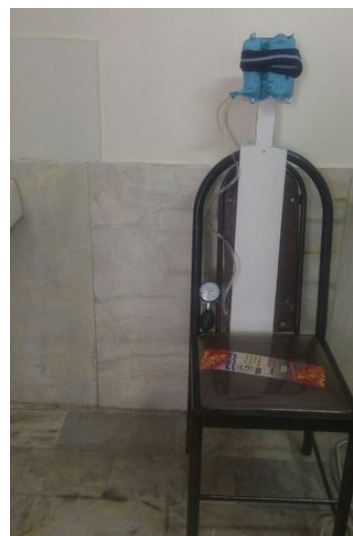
Chair for MVIC during ultrasonography.
